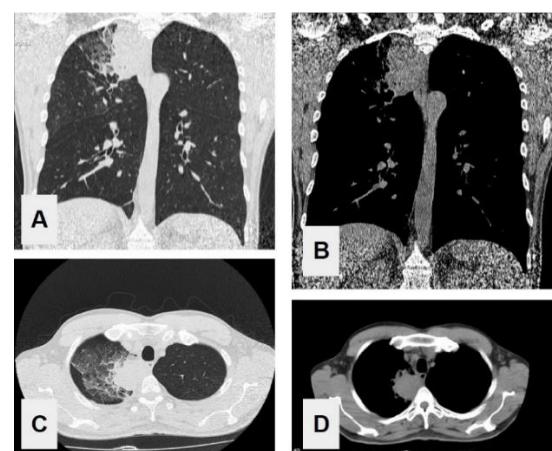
Preoperative non-enhanced computed tomography showing mass of 47 x 50.5 mm in axial (C, D) and coronal (A, B) planes, which is in intimate contact with the esophagus.
